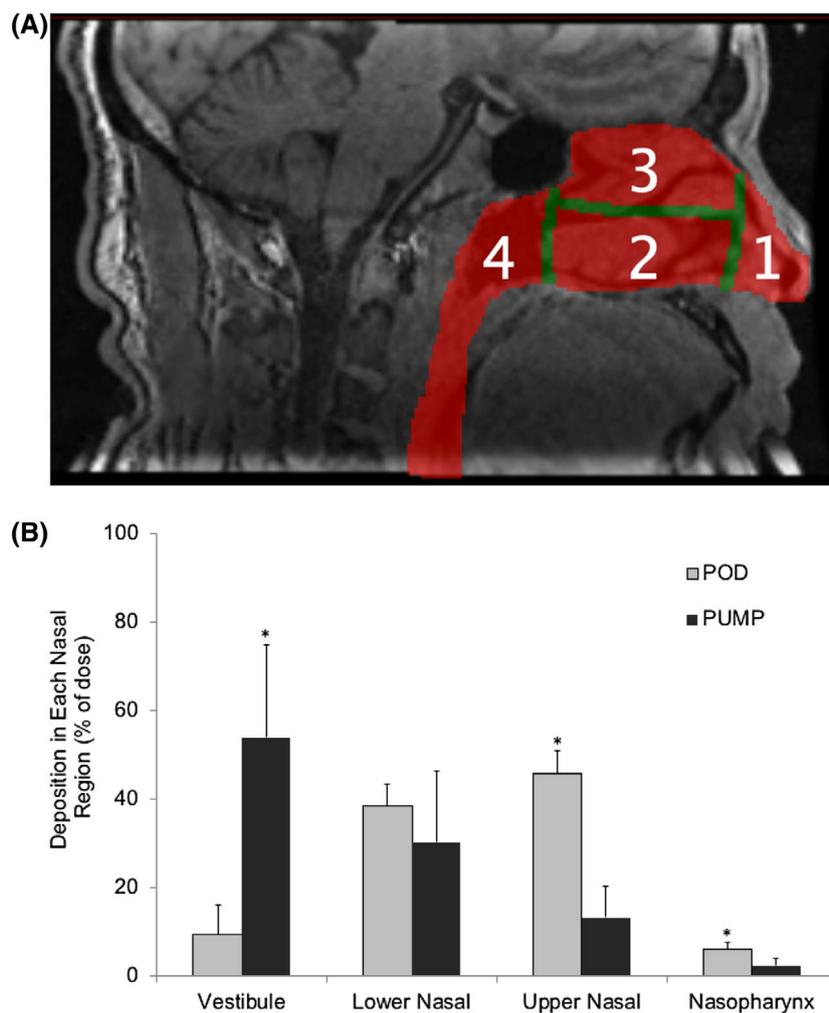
Intranasal delivery of MAG-3 (technetium-99m labeled peptide) by POD vs a nasal pump as determined by SPECT imaging in 7 healthy subjects.⁸⁸ (A) For the determination of nasal deposition, the nasal cavity was sectioned into the nasal vestibule (1), the lower turbinate region (2), the upper turbinate/olfactory region (3), and the nasopharynx (4). These sections were defined based on the nasal anatomy observed in MRI images. (B) Nasal deposition quantitation. The POD device led to significantly ($*P < .05$) higher deposition in the upper nasal cavity/olfactory region (upper nasal) compared to the traditional PUMP. A majority of the PUMP dose was administered into the vestibule region.⁸⁹
